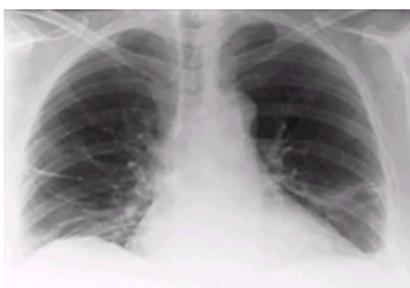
Discoid or plate-like atelectasis, also called atelectatic pneumonitis, is perhaps the most common chest roentgenographic finding in patients with chronic systemic lupus erythematosus. Diffuse interstitial process is distinctly uncommon.
